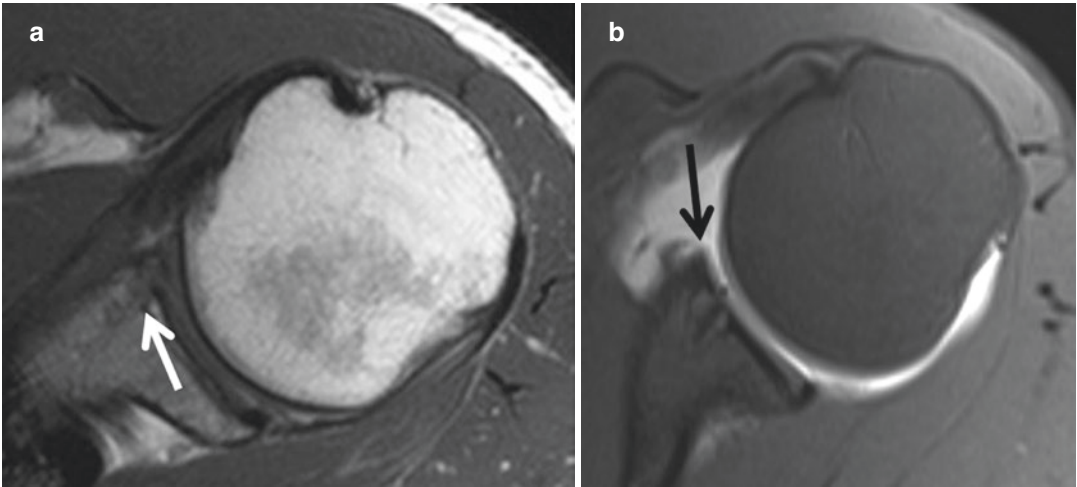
Postoperative anterior labral tear, noncontrast vs. direct MR arthrography. (a) Axial proton density image from a noncontrast MRI in a patient status post-anterior labral debridement shows abnormal signal intensity of the subchondral bone (arrow) related to postsurgical changes from the suture anchor; however, lack of joint
